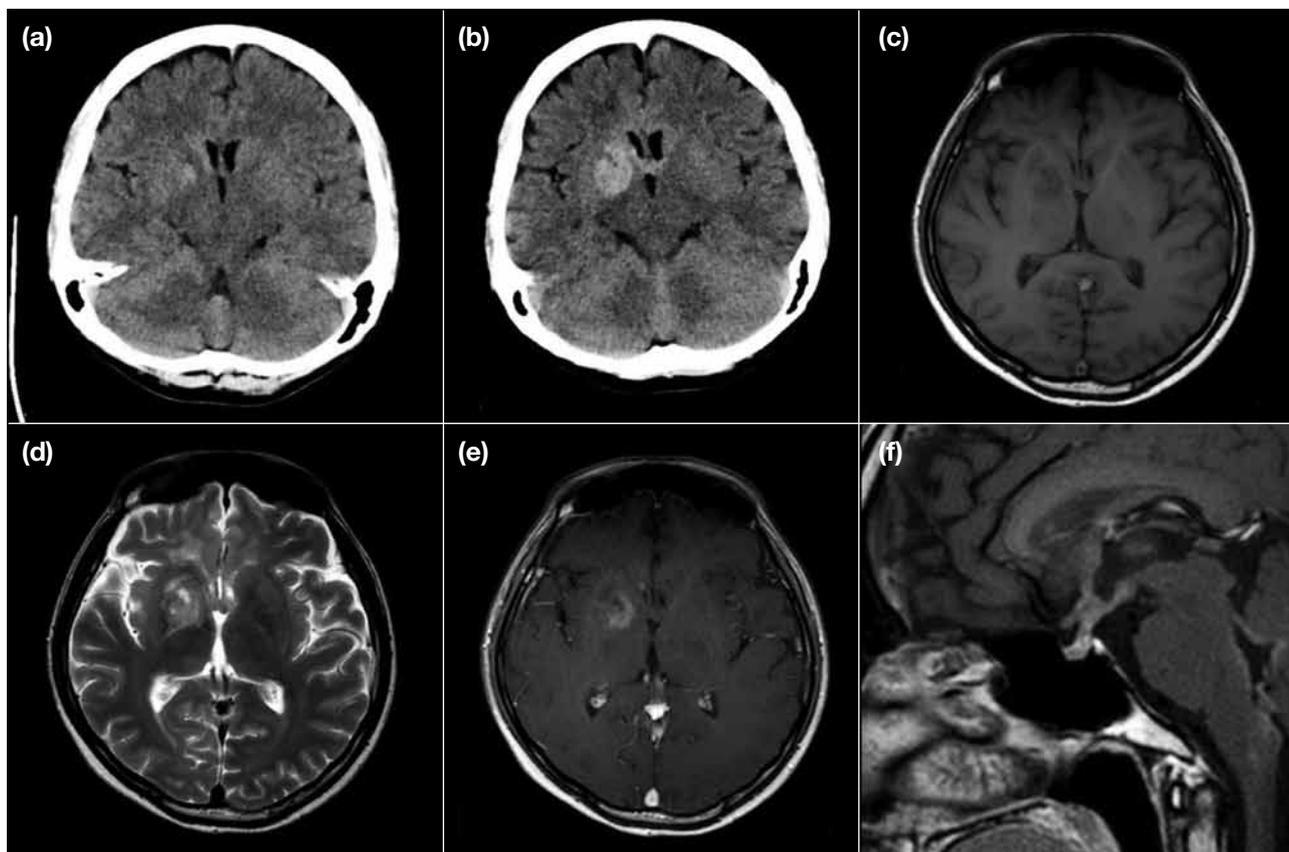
Case 2. 19-year-old male patient. (a) Initial computed tomography (CT) of the brain (June 2015) showed focal hyperdense lesion in the right globus pallidus. (b) Follow-up CT of the brain (May 2016) showed an interval enlargement of the hyperdense lesion occupying the right lentiform nucleus. Repeated magnetic resonance imaging (MRI; May 2016) (c) axial T1-weighted, (d) T2-weighted, and (e) post-contrast T1-weighted images demonstrated the mixed cystic and solid appearance of the right lentiform nucleus lesion. (f) The patient then developed diabetes insipidus and cortisol insufficiency; subsequent MRI (June 2016) sagittal post-contrast T1-weighted image of the pituitary gland demonstrated abnormal thickening of the pituitary stalk with contrast enhancement extending to hypothalamus.
